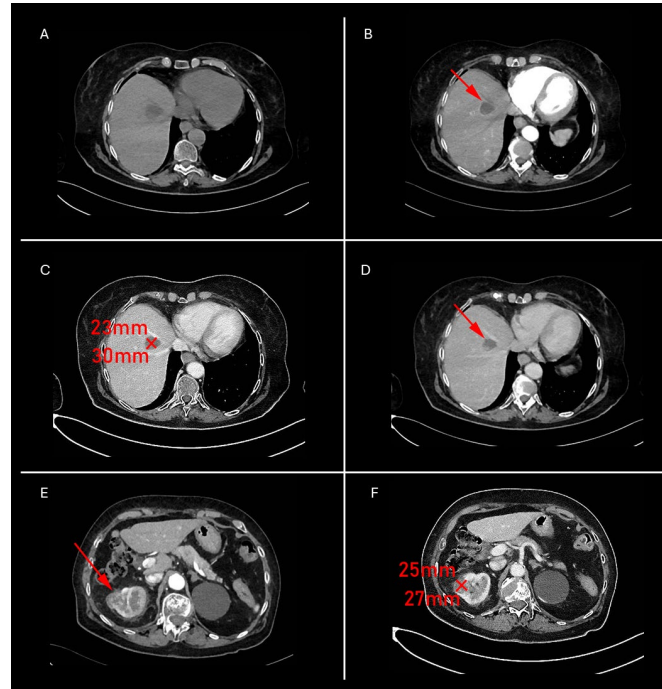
CT scan at 5-month follow-up. (A–D) Hepatic lesion (HCC): (A) non-contrast phase; (B) arterial phase showing persistent arterial hyperenhancement (red arrow); (C) venous phase demonstrating increased lesion size ( $68 \times 73$  mm); (D) delayed phase showing central hypodensity and reduced contrast enhancement consistent with intratumoral necrosis and pseudoprogession (red arrow). (E,F) Renal lesion (RCC): (E) arterial phase showing partial response (red arrow); (F) venous phase showing significant size reduction ( $29 \times 27$  mm vs.  $45 \times 40$  mm).
